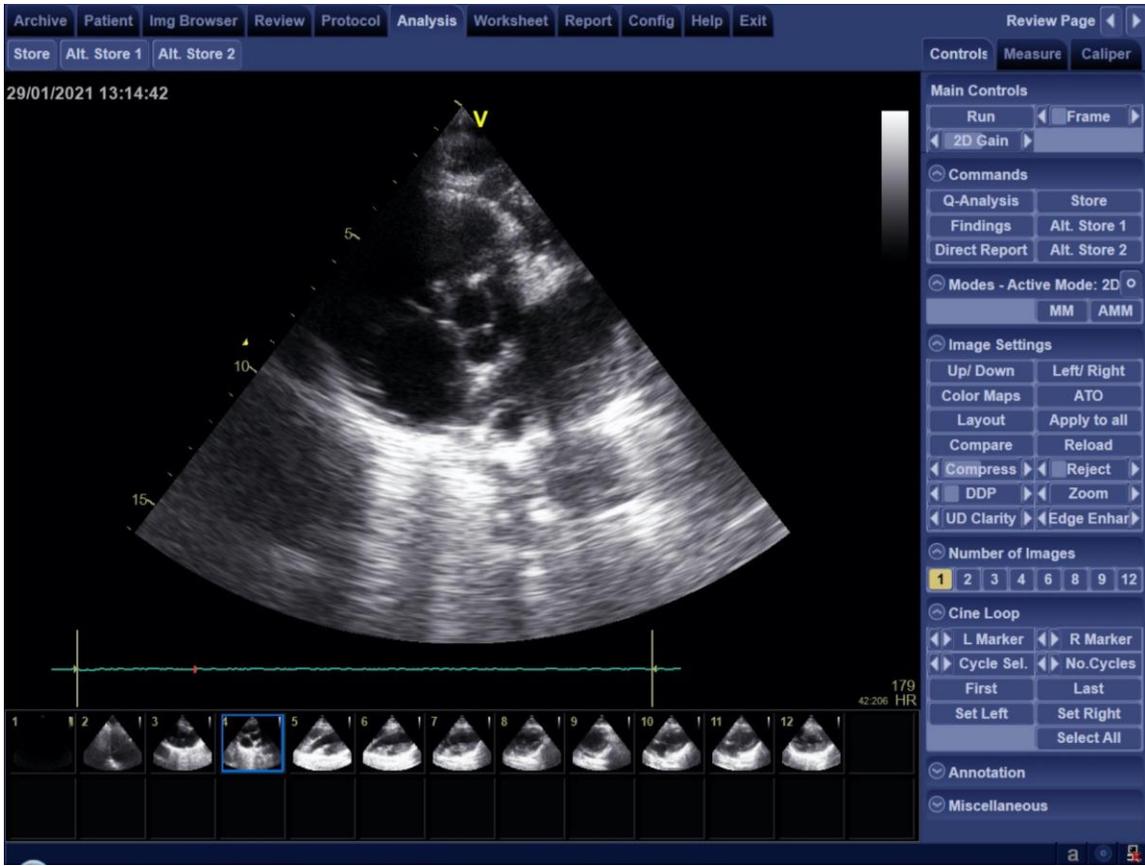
Parasternal short axis (PSAX) of the aortic root, representative of the superior-inferior site of Standard Chest Compression (SCC).
